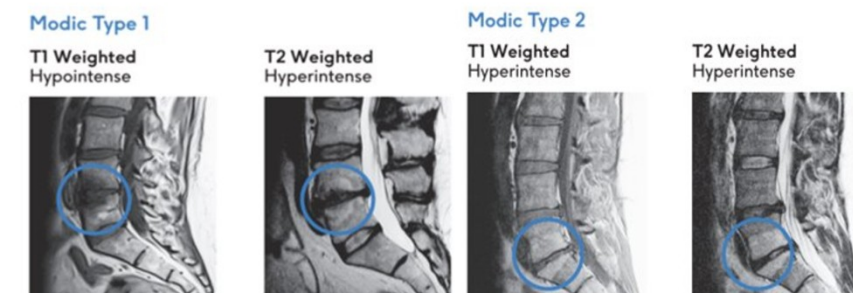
Modic changes seen on MRI. From *Modic Indication Card*, by Intracept by Relevant. n.d., <https://www.relevant.com/resources/modic-changes/>. Copyright 2023 by Intracept by Relevant.
